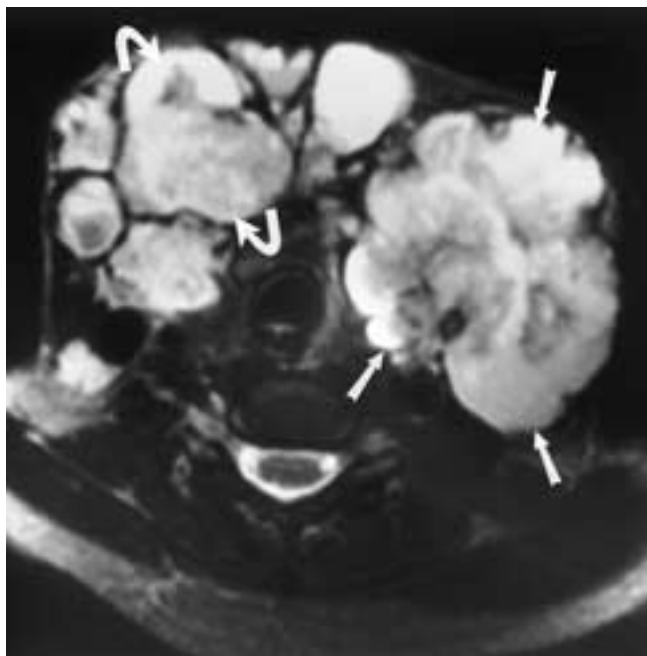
Papillary carcinoma developing within a goitrous gland. Axial T2-weighted MR image shows multiple demarcated solid and cystic nodules/masses diffusely within the thyroid gland. The large predominantly solid nodule replacing the left gland (*arrows*) and the dominant nodule in the right lobe (*curved arrows*) represented papillary carcinoma at pathology.
